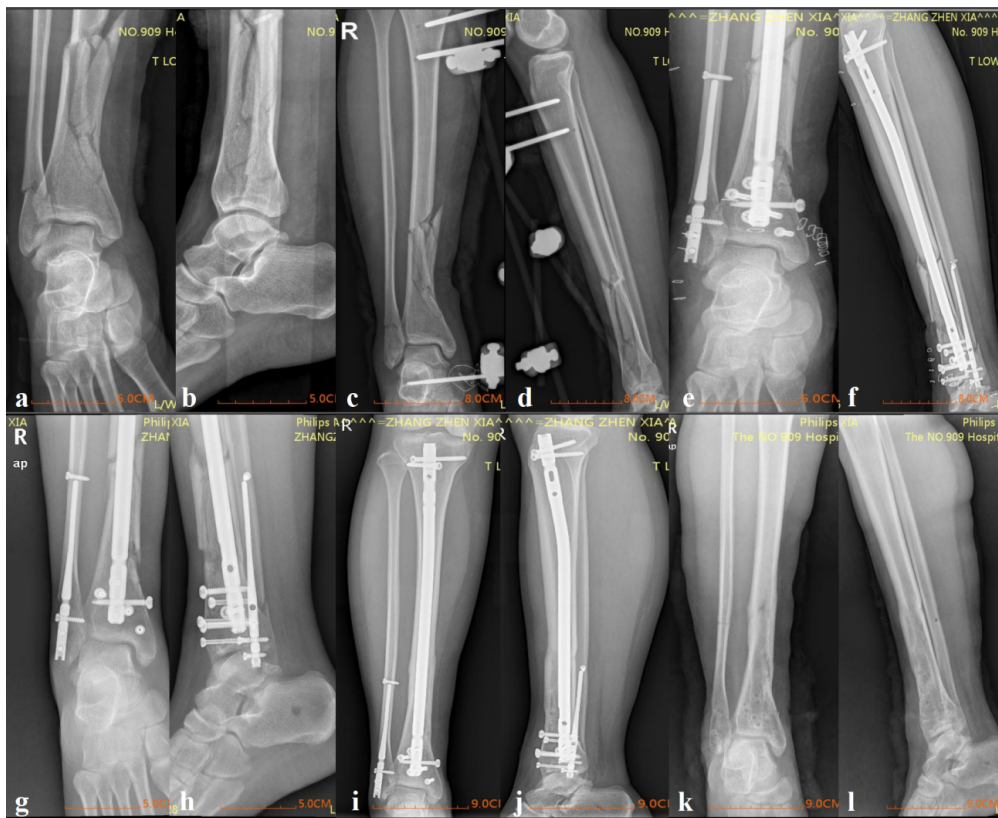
Representative images of patient 9 (36-year-old female patient with a Gustilo IIIa fracture resulting from a heavy object crush). — a,b: X-rays at admission. c,d: X-rays of temporary external fixation. e, f: X-rays after 4 days of simultaneous fixation of the fibula and tibial intramedullary nail. g, h: Follow-up X-rays after 2 months. k, l: Follow-up X-rays after 4 months. i, j: Removal of all implants after 12 months.
